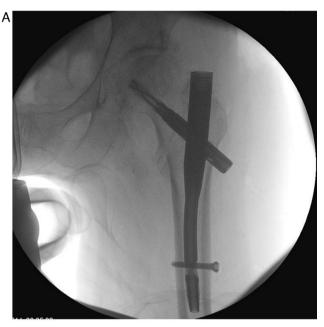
Intraoperative radiographic control: anteroposterior and profile.
